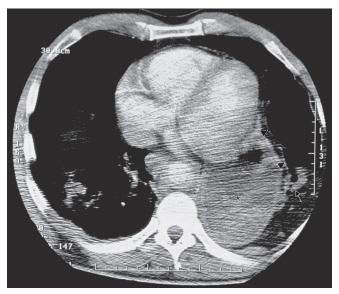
Spiral chest CT pattern of combined blunt lesions of the diaphragm and diaphragmatic aorta in a 45-year-old male patient involved in a high-speed deceleration car crash. The blunt traumatic aortic injury features irregularity and blurring of the aortic contour, with surrounding mediastinal hematoma. The left diaphragm rupture allows for an intrathoracic herniation of the stomach (asterisk), small (arrow) and large (arrowheads) bowel loops. Note the streak artifacts produced by the patient's arms left along his chest because of a humeral fracture
